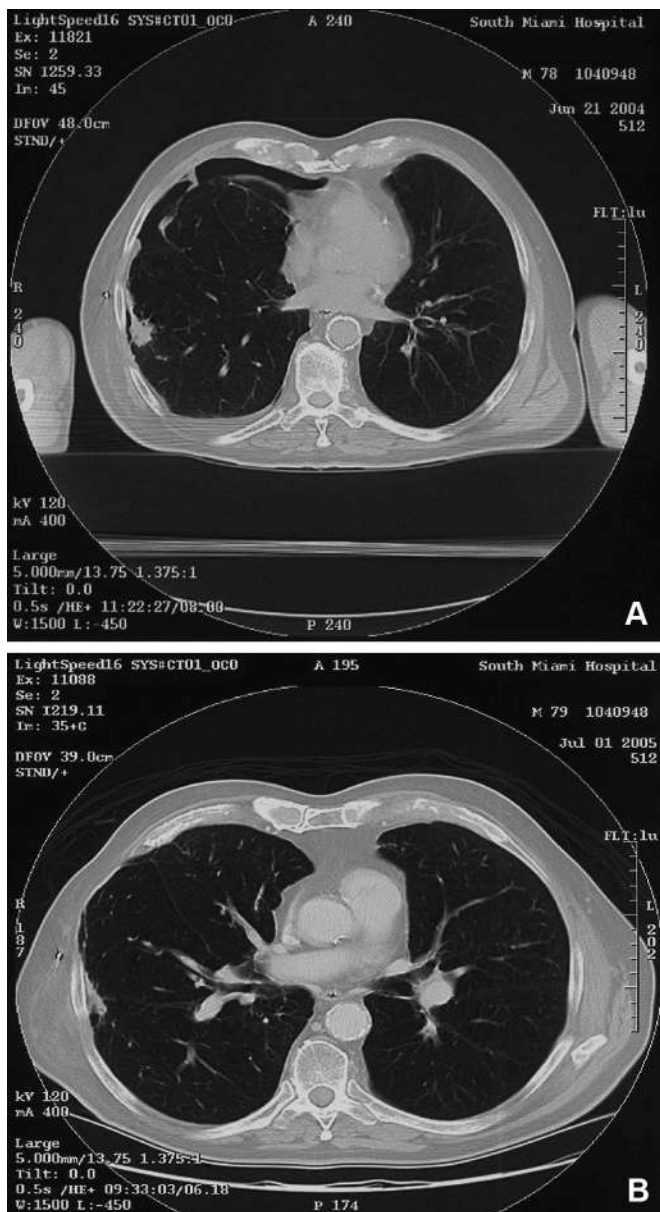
(a) Chest CT scans 1 month before CyberKnife treatment and (b) 1 year after treatment.
